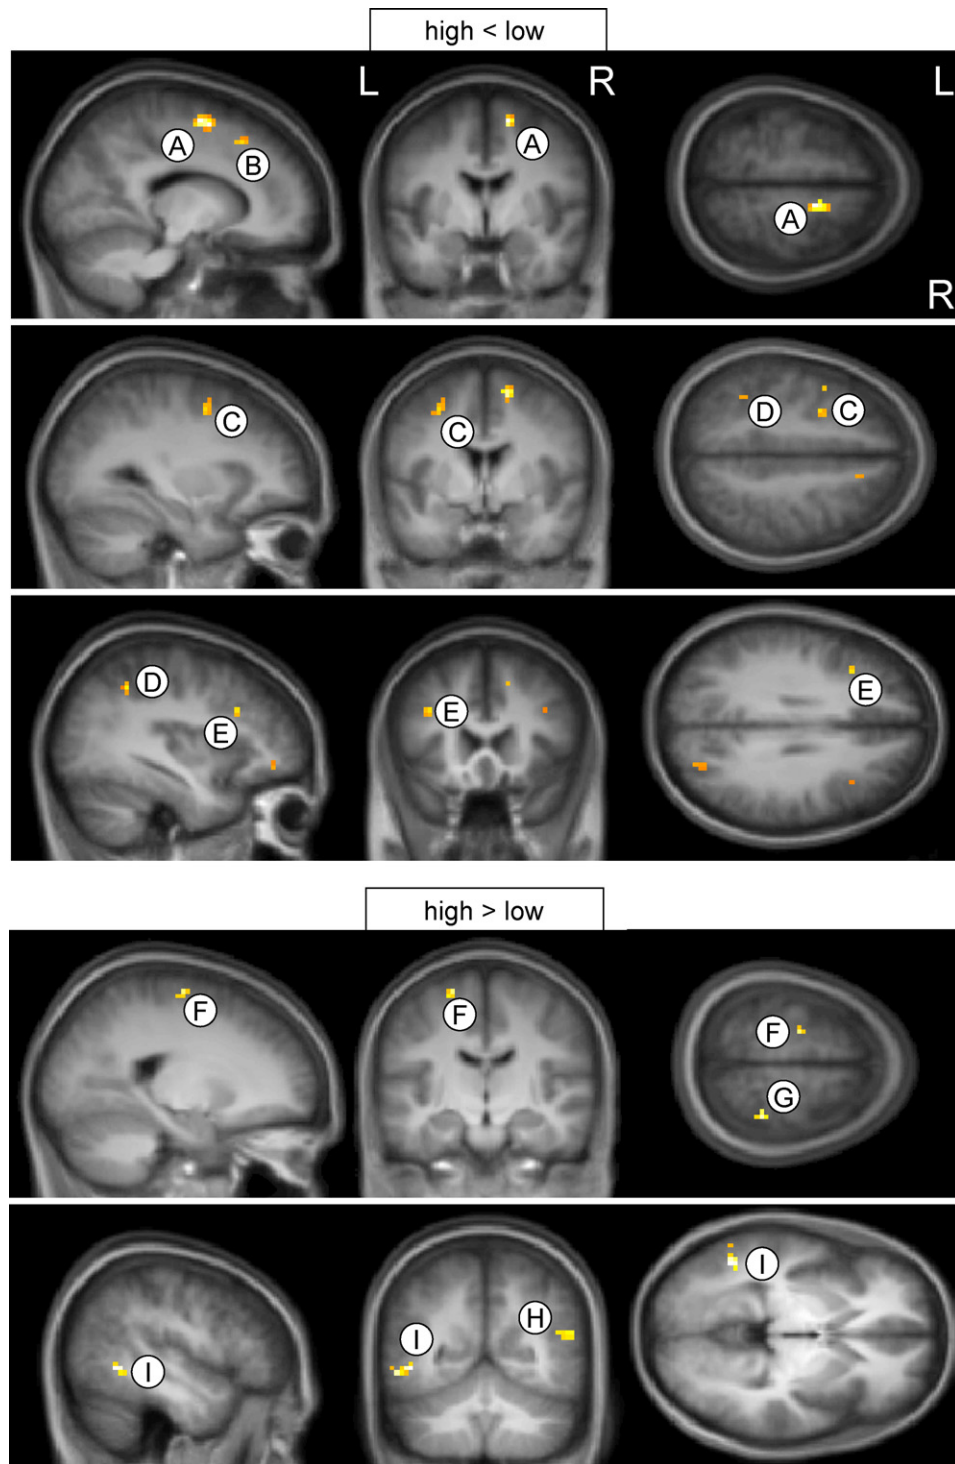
Brain regions showing reduced (top panels) and increased (bottom panels) BOLD signal in OCS high vs. low twins for the 'planning vs. baseline' contrast. Clusters of significant difference are overlaid on an averaged structural MRI across all twins.
